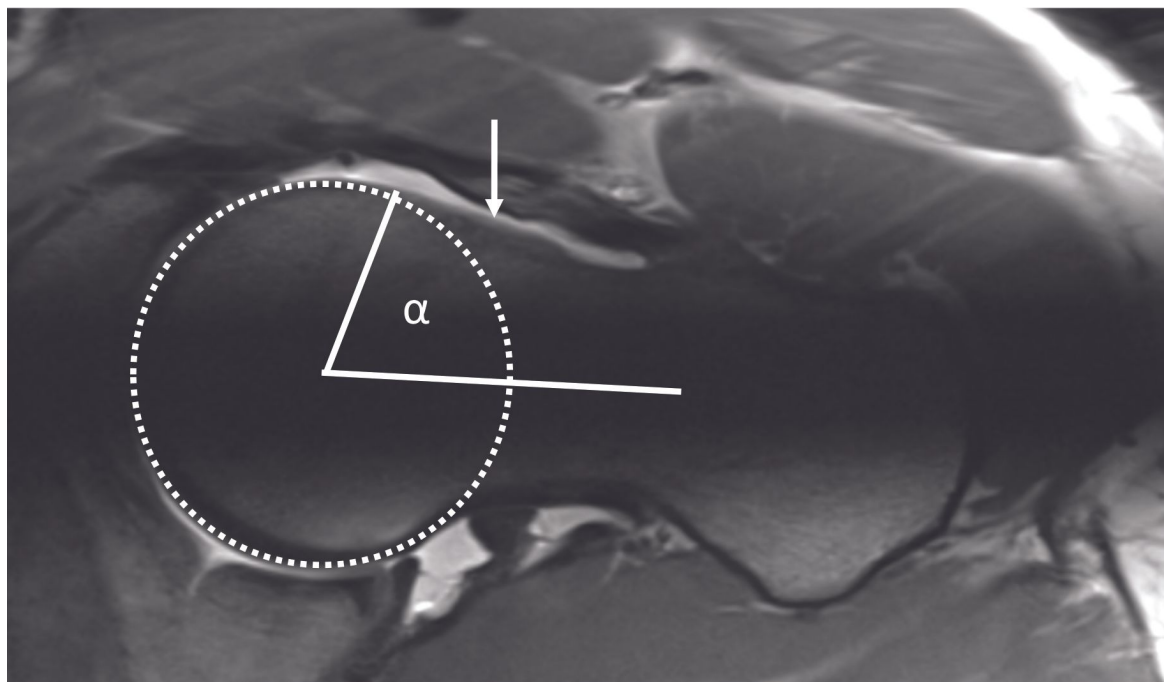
Cam effect. Arthro-MRI can be used to locate and quantify the filling of the cervico-cephalic junction that causes the cam effect. The alpha angle can also be measured on this modality.
